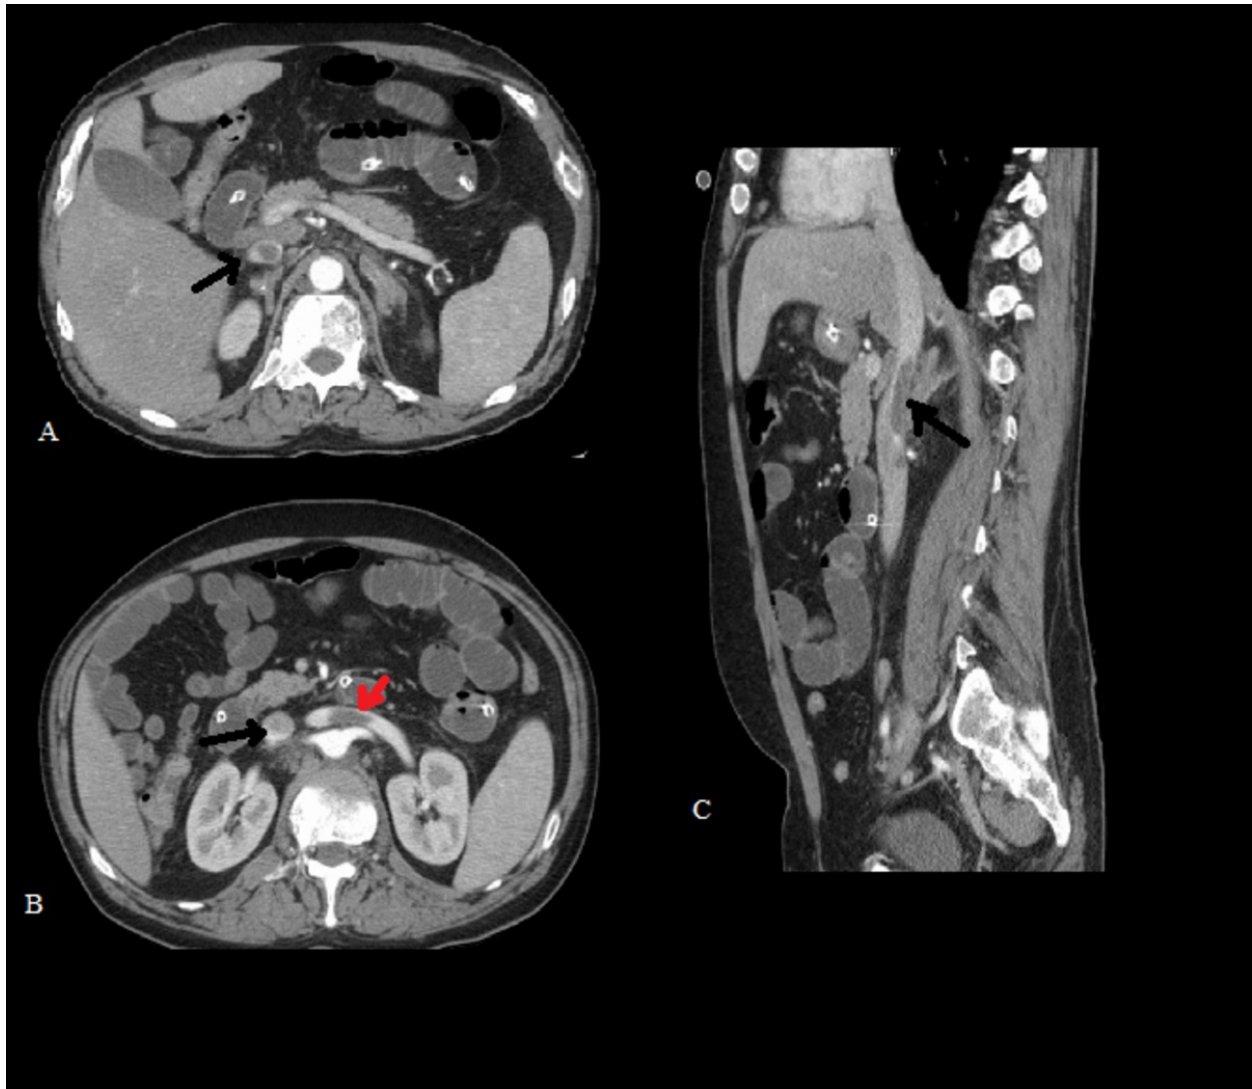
Bland Thrombosis of the IVC: During the course of a computed tomography enteroclysis (axial (A,B) and sagittal (C) reformations) was revealed a small filling defect, compatible with non-occlusive thrombus, in the IVC (black arrow) and left renal vein (red arrow).
